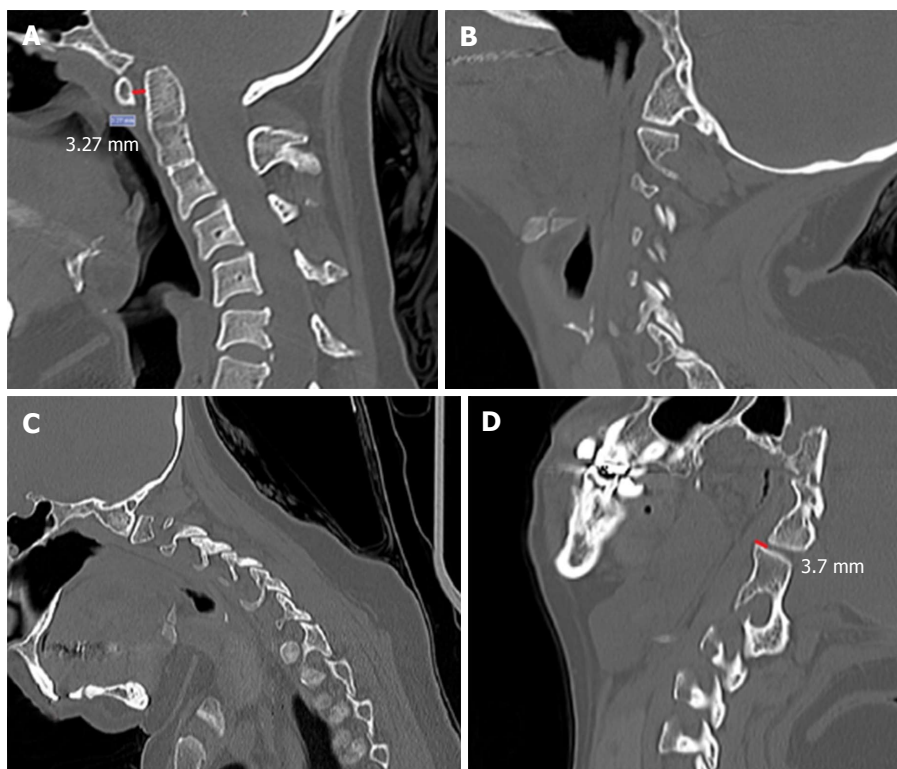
Forty-year-old woman with a tonsillar herniation of 5 mm and basilar invagination. Noted that she also had atlas assimilation and a congenital C2/3 fusion A, B and C: Pre-operative dynamic imaging, showing a atlanto-dental interval of 3.27 mm, but no signs of facet dislocation in flexion or in extension (B and C); D: Sagittal computed tomography scan obtained after some months after posterior fossa decompression showing an evident facet joints dislocation (the assimilated lateral mass of C1 was dislocated posteriorly over the superior facet joint of C2). She had some symptoms of dizziness and cervical pain when flexing the neck and an occipito-cervical fixation was proposed but the patient declined surgical treatment because she was not doing well with depression and mood disorders.
